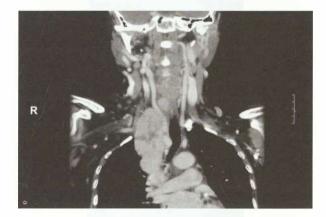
CT neck and chest showing the large mass displacing the carotid artery, internal jugular vein thrombosis and mediastinal lymph nodes. Lymph nodes were cleared after sternotomy
